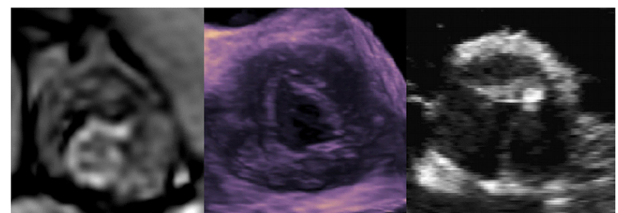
Functionally unicommissural unicuspid aortic valve with RCC/NCC and RCC/LCC raphe. Left panel: CT with RCA ostium seen anteriorly. Middle panel: 3D TOE reconstruction. Right panel: TTE PSAX.
